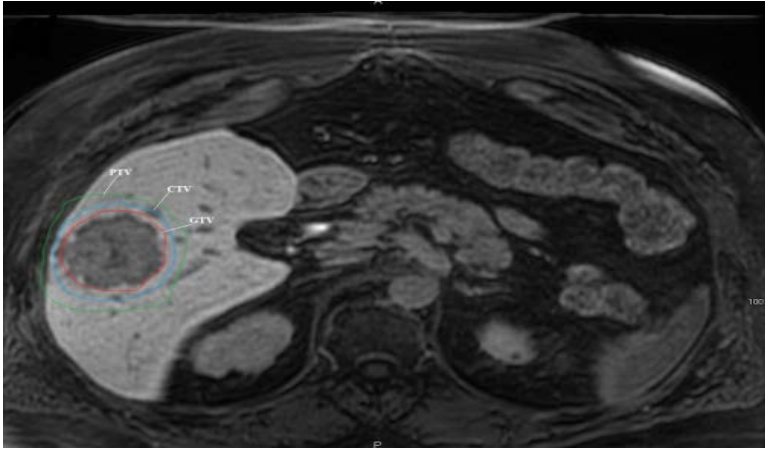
Image from a radiotherapy treatment planning procedure for a patient with a liver tumor. The gross tumor volume (GTV; red) is defined on the contrast-enhanced CT, the clinical target volume (CTV; blue) is a 2-mm expansion on the GTV, and the planning target volume (PTV; green) [79].
